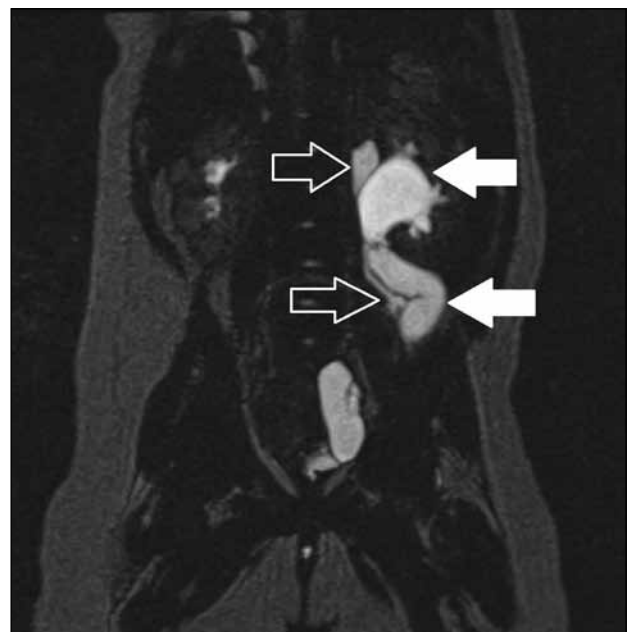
Patient A. Static coronal maximum intensity projection image of magnetic resonance urogram in T2-weighted turbo spin echo three-dimensional respiratory-triggered sequence showing the left duplex kidney with dilated pelvicalyceal system and ureters; the lower moiety renal pelvis and ureter are indicated by the white arrows while the upper moiety renal pelvis and ureter are indicated by the empty white arrows.
